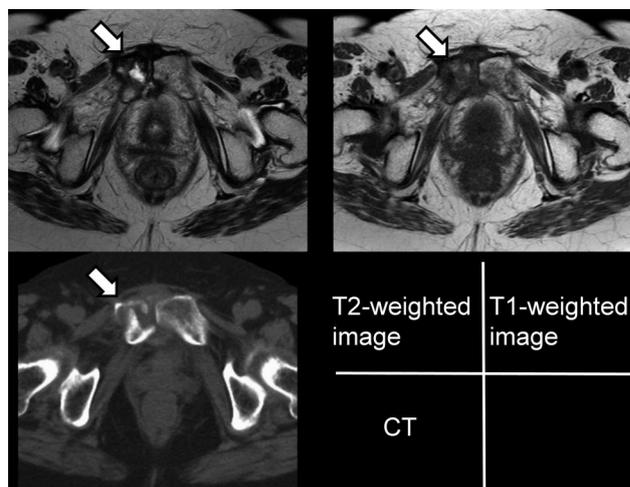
Pelvic MRI shows a high-intensity signal in the T2-weighted image and a low-intensity signal in the T1-weighted image in the right pubis. Pelvic CT shows cortical fractures in the right pubis.
